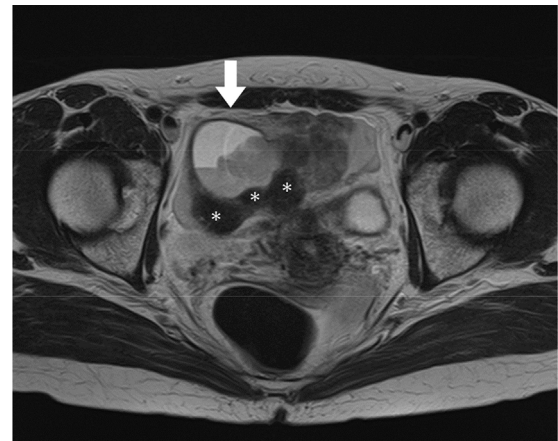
T2-weighted image showing a cystic lesion with a low-signal component located dorsally (arrow). The cyst was adjacent to a low-signal mass suggestive of a typical leiomyoma (*). The high-attenuation area found on the plain CT image showed a mixed signal. CT, computed tomography.
